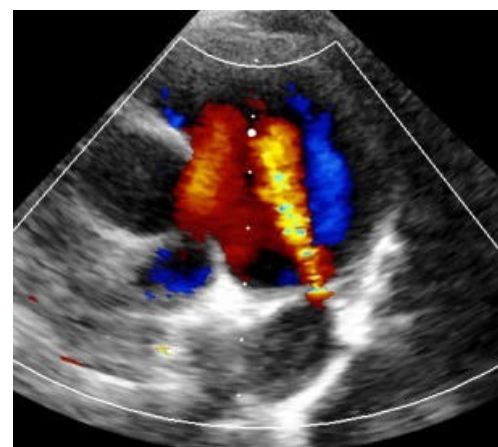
Transthoracic echocardiogram showing PDA with left-to-right shunt.
